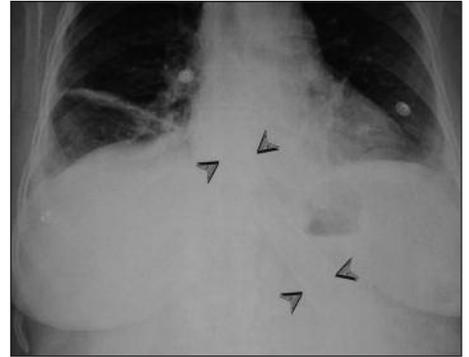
Postero-anterior chest radiograph; stent in the esophagus after first procedure.
